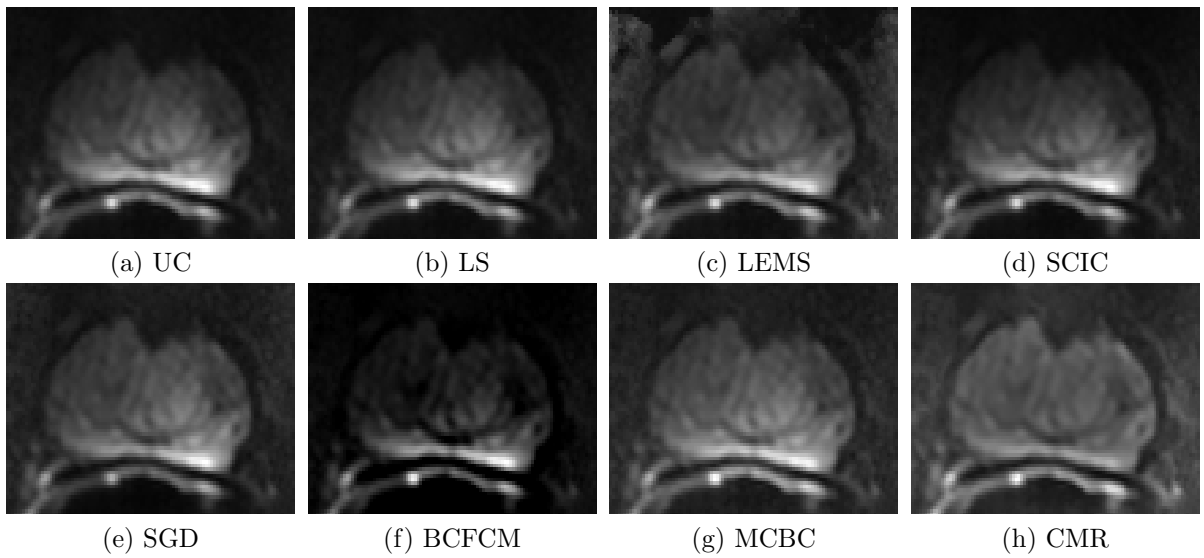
Case 2 with $b=1000 \text{ s/mm}^2$. Proposed CMR imaging reduces the bias field and noise in prostate DWI.
